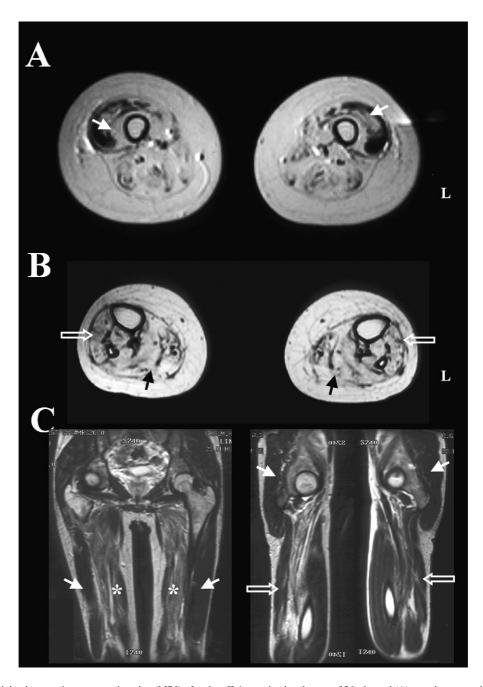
Muscle T1-weighted magnetic resonance imaging (MRI) of patient II-1 examined at the age of 36, showed (A) prominent atrophy and fatty infiltration in the thigh muscles, including the quadriceps (arrows) at the middle thigh level, (B) severe atrophy and fatty replacement, including the gastrocnemius (black arrows) and tibialis anterior (open arrows) muscles at the distal leg level. Muscle MRI study of patient II-3 examined at the age of 24, showed (C) fatty infiltration in the adductor muscles (asterisks) and anterior tibialis muscles (open arrows) with preservation of the quadriceps muscles (arrows).
